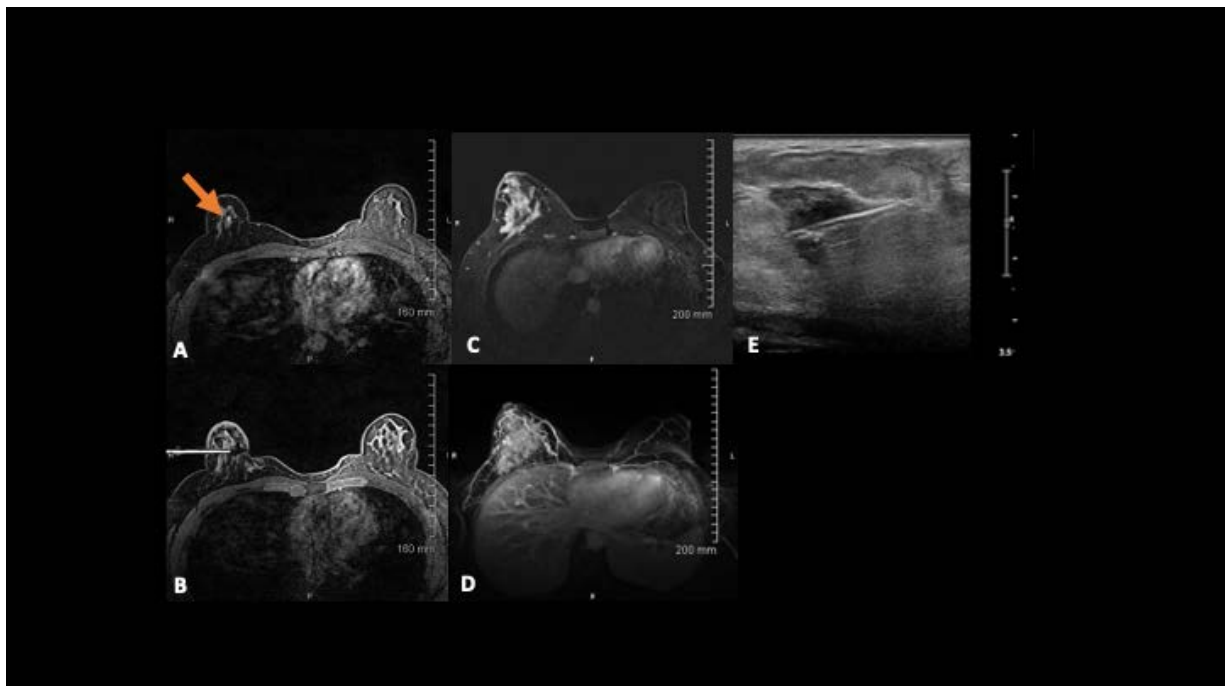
a–e. Delayed cancer diagnosis due to failure in follow-up of a false negative MRI biopsy. A 35-year-old female with positive breast cancer gene (BRCA1). a. Screening MRI axial post contrast subtraction imaging shows a 9mm irregular mass with delayed washout curve at 12:00 of right breast, 3cm from the nipple. b. MRI biopsy was performed. Initial biopsy: concordant benign pathology—non-proliferative fibrocystic changes with dense fibrosis. Follow-up MRI 14 months later (patient had difficulty scheduling MRI due to insurance issues). c, d. Axial post contrast subtraction and maximum intensity projection images show large volume diffuse non-mass enhancement measuring 69mm, occupying the entire right breast. e. Ultrasound biopsy was performed. Repeat biopsy: concordant malignant pathology—Infiltrating poorly differentiated grade 3 ductal carcinoma.
